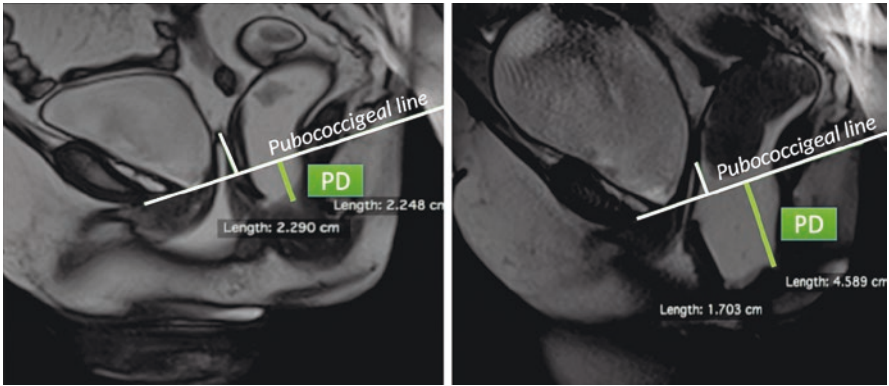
Resting and straining phases observed with dynamic magnetic resonance imaging. *PD* perineal descent
